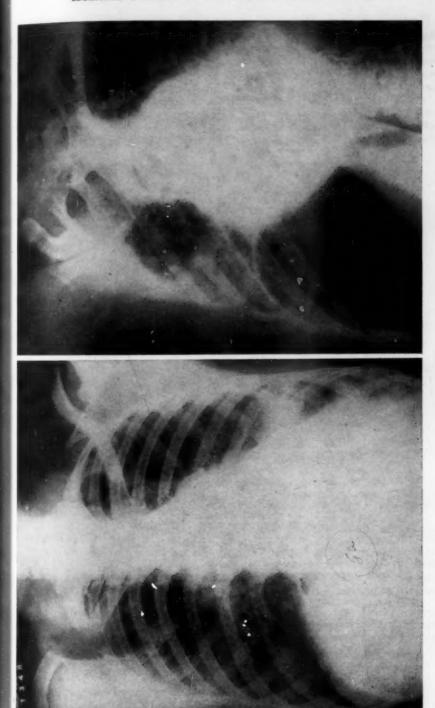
A. X-ray of the chest in case 6 shows diffuse pulmonary infiltration and prominence of the pulmonary artery. B. Angiocardiogram in case 6, three seconds after injection of contrast medium, shows visualization of the pulmonary aneurysm.
